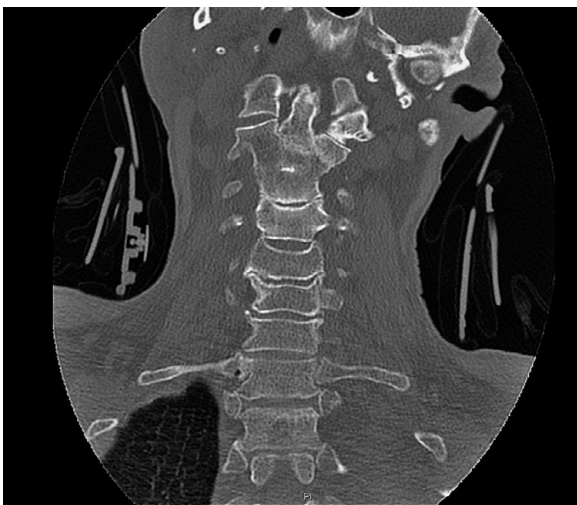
Coronal CT scan cervical spine
